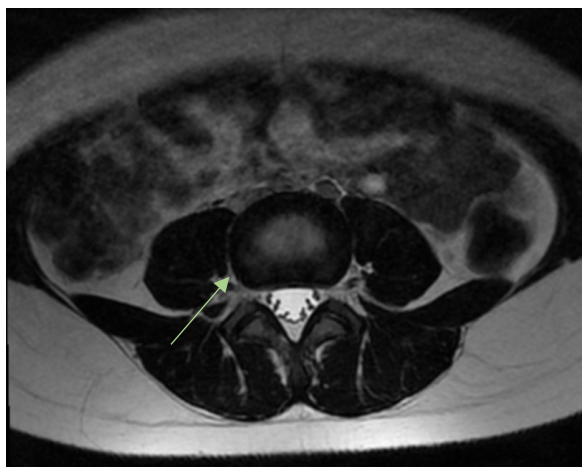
Second MRI of the lumbar spine T2 AXIAL
